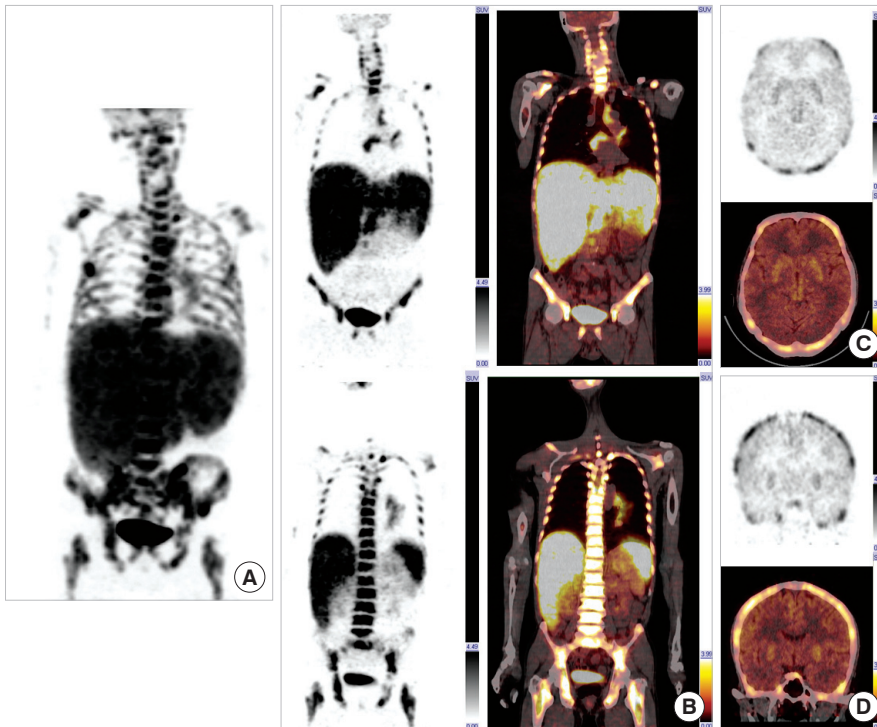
¹⁸F-FDG PET/CT demonstrated focal hypermetabolic lung mass in left lower lobe with diffuse and intense hypermetabolism throughout the skeleton and liver. Interestingly, skeletal muscles of limbs, mediastinum, bowel, and especially brain showed very low FDG uptake. (A) Maximal intensity projection image. (B) Coronal images of torso. (C) Transaxial image of brain. (D) Coronal image of brain.
